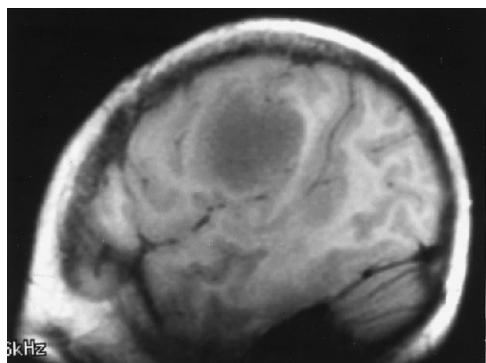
Sagittal MR image in another frontal lobe tumor. The central sulcus was not identified in sagittal or axial images. Activation was identified ventral to this tumor.
